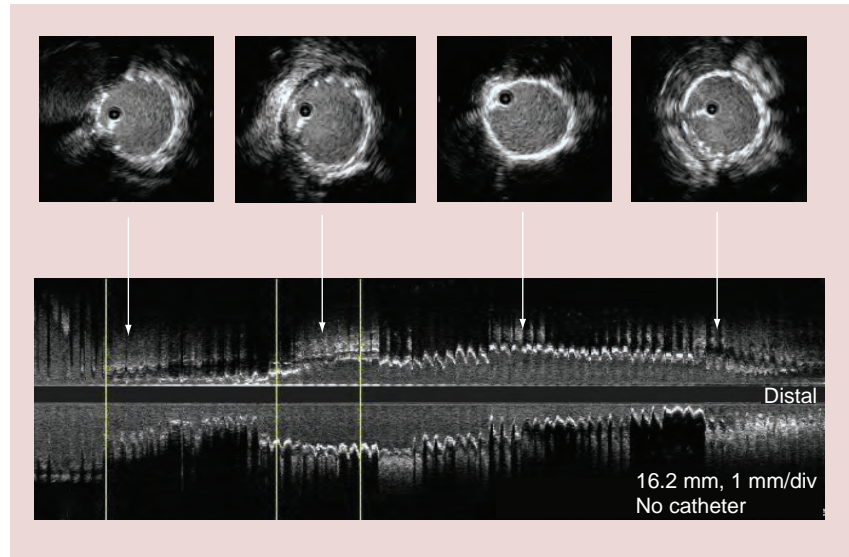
Intravascular ultrasound analysis postpercutaneous coronary intervention. Intravascular ultrasound analysis after stent apposition, showing an optimal covering of the ulcerated plaque with closure of the cavities (arrows: approximate correspondence of the intravascular ultrasound slices with longitudinal reconstruction).
